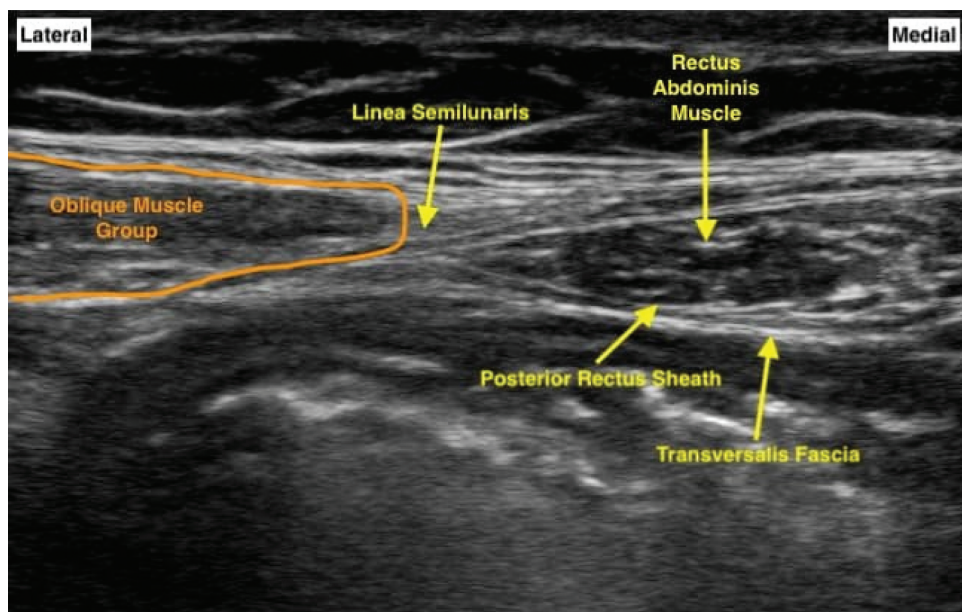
Ultrasound view of the rectus sheath plane.
